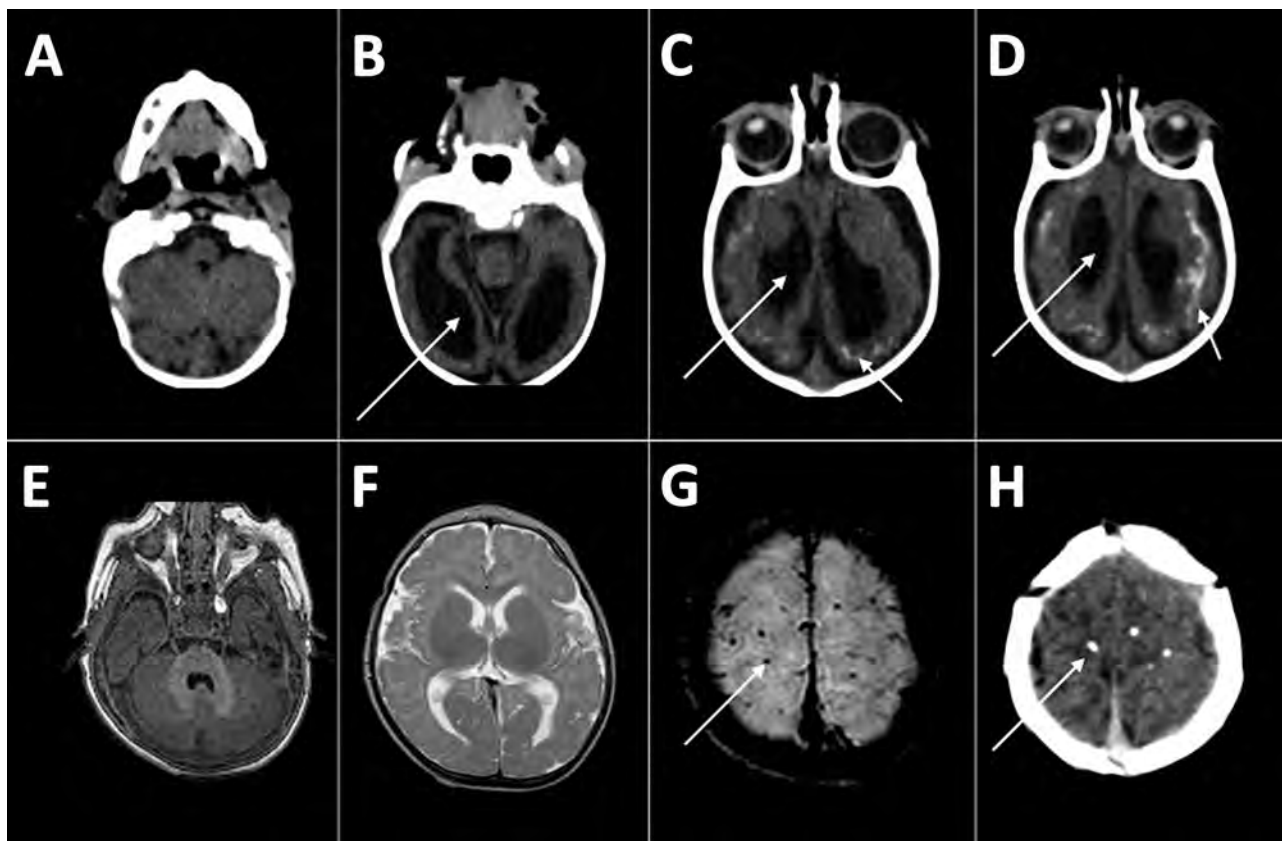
Computed tomography radiographs of the brains of 2 infants with dysphagia and microcephaly caused by congenital Zika virus infection, Brazil, 2015. A–D) Images for patient 4 show malformation of cortical development, ventriculomegaly (long arrows), and calcifications in cortical and subcortical white matter in transition between cortex and white matter (short arrows). E–H) Images for patient 6 show no malformation of cortical development or ventriculomegaly, but calcifications are visible in the cortical area (arrows).
